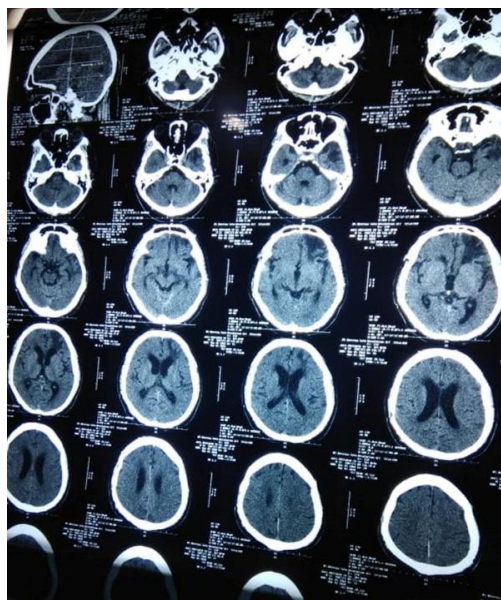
Initial Non-contrast Head Computed Tomography Scan
